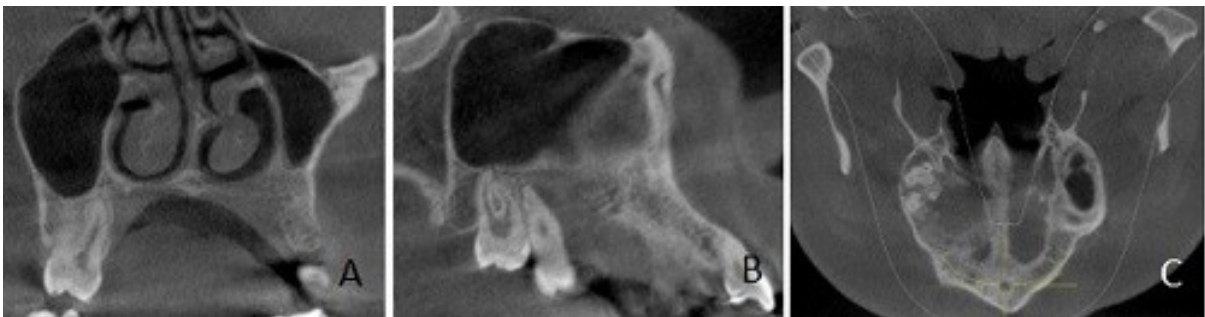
CBCT image of the lesion at 6 months after enucleation. A: Coronal cross-section. B: Sagittal cross-section. C: Axial cross-section.
